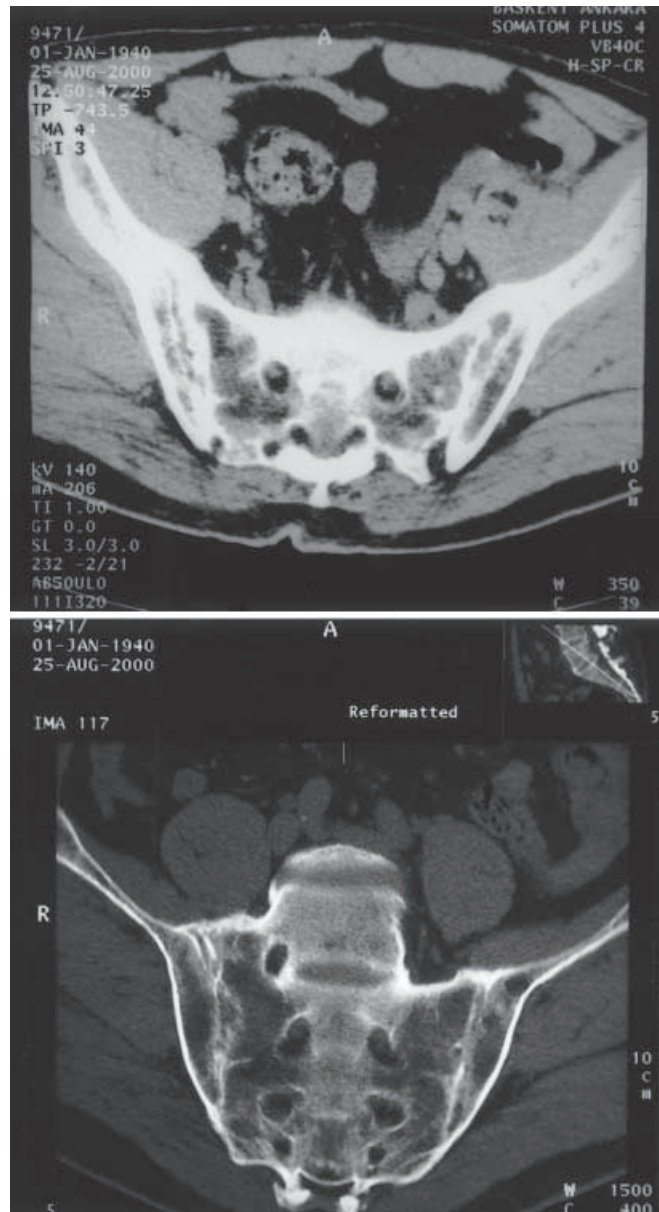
Computed tomography showing chronic sacroiliitis of both sacroiliac joints
